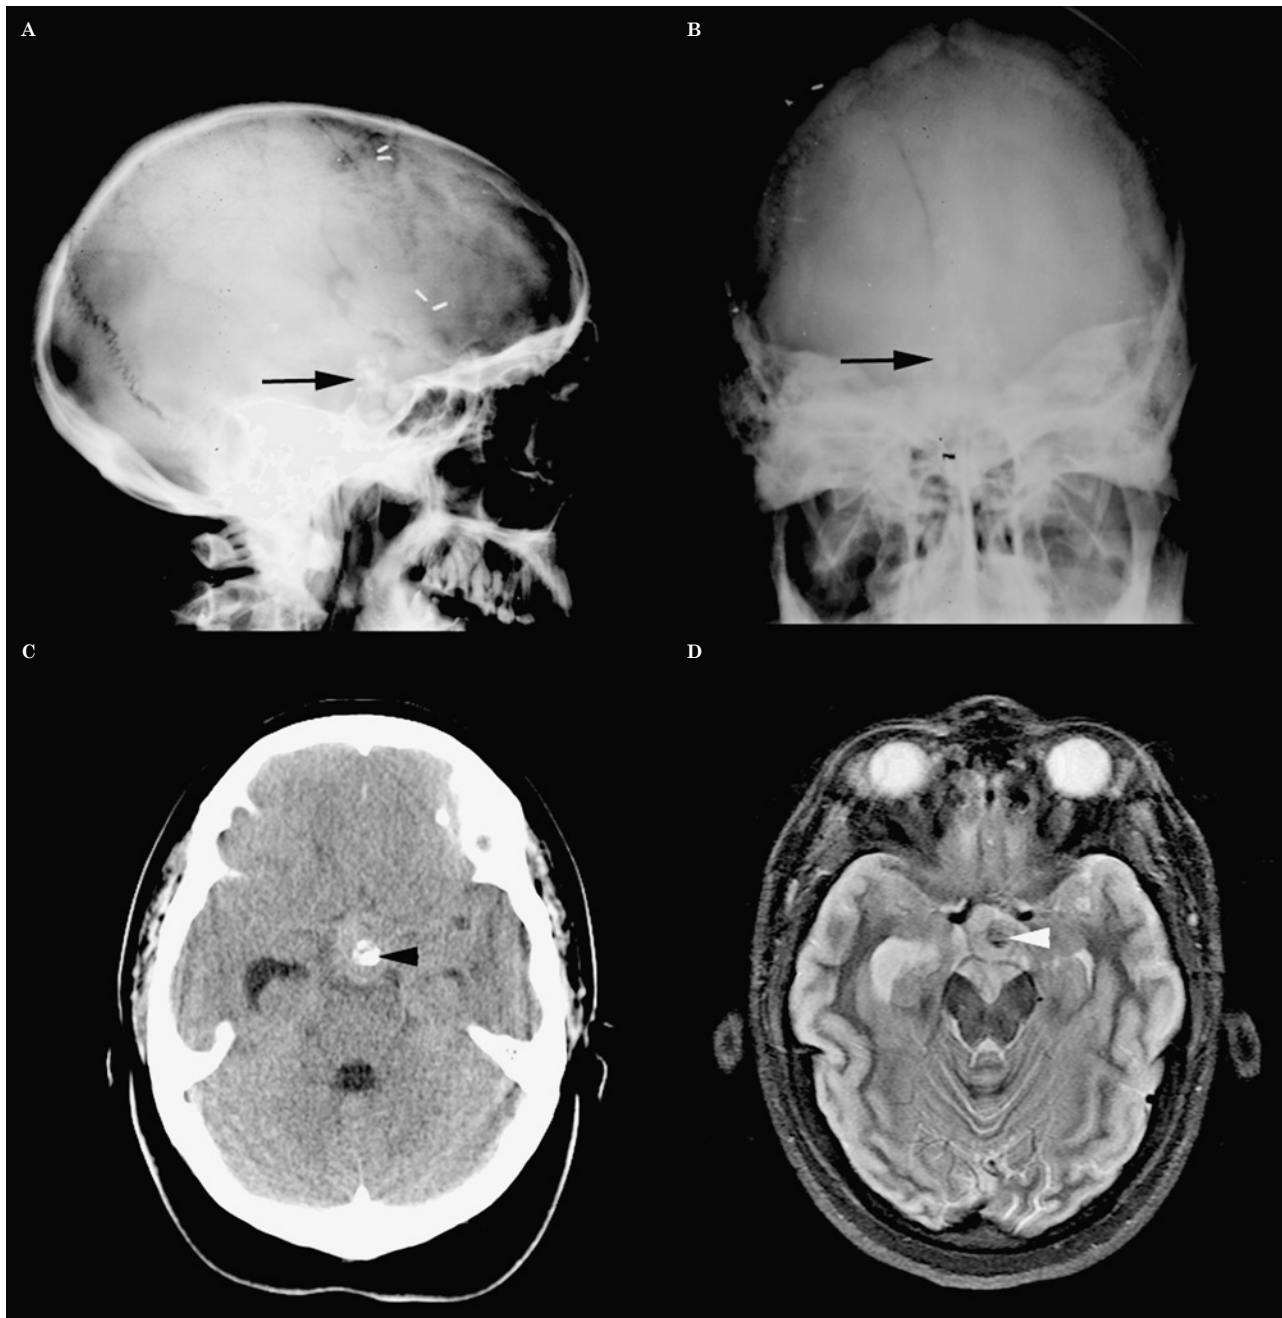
Craniopharyngoma. Lateral (A) and frontal (B) radiograph of the skull demonstrate a calcified mass (arrows) occupying an enlarged sella turcica and extending upwards into the suprasellar cistern. This represented local recurrence of a craniopharyngoma surgically treated years before. C) Non contrast CT shows coarse calcifications (arrowhead) within a suprasellar mass in a different patient. Axial T2W image at the same level demonstrates signal void from the calcifications (arrowhead) within the mass (D).
